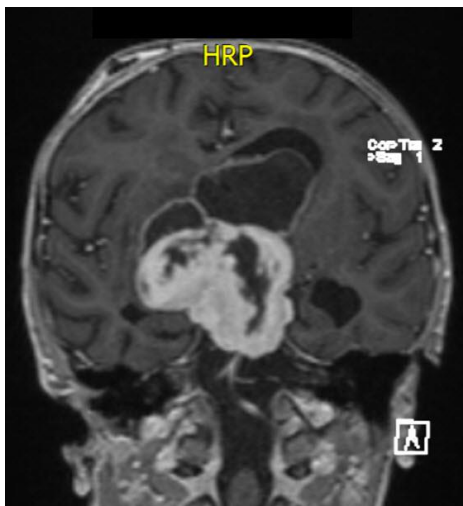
Postoperative (1st step), coronal post-contrast MRI.
